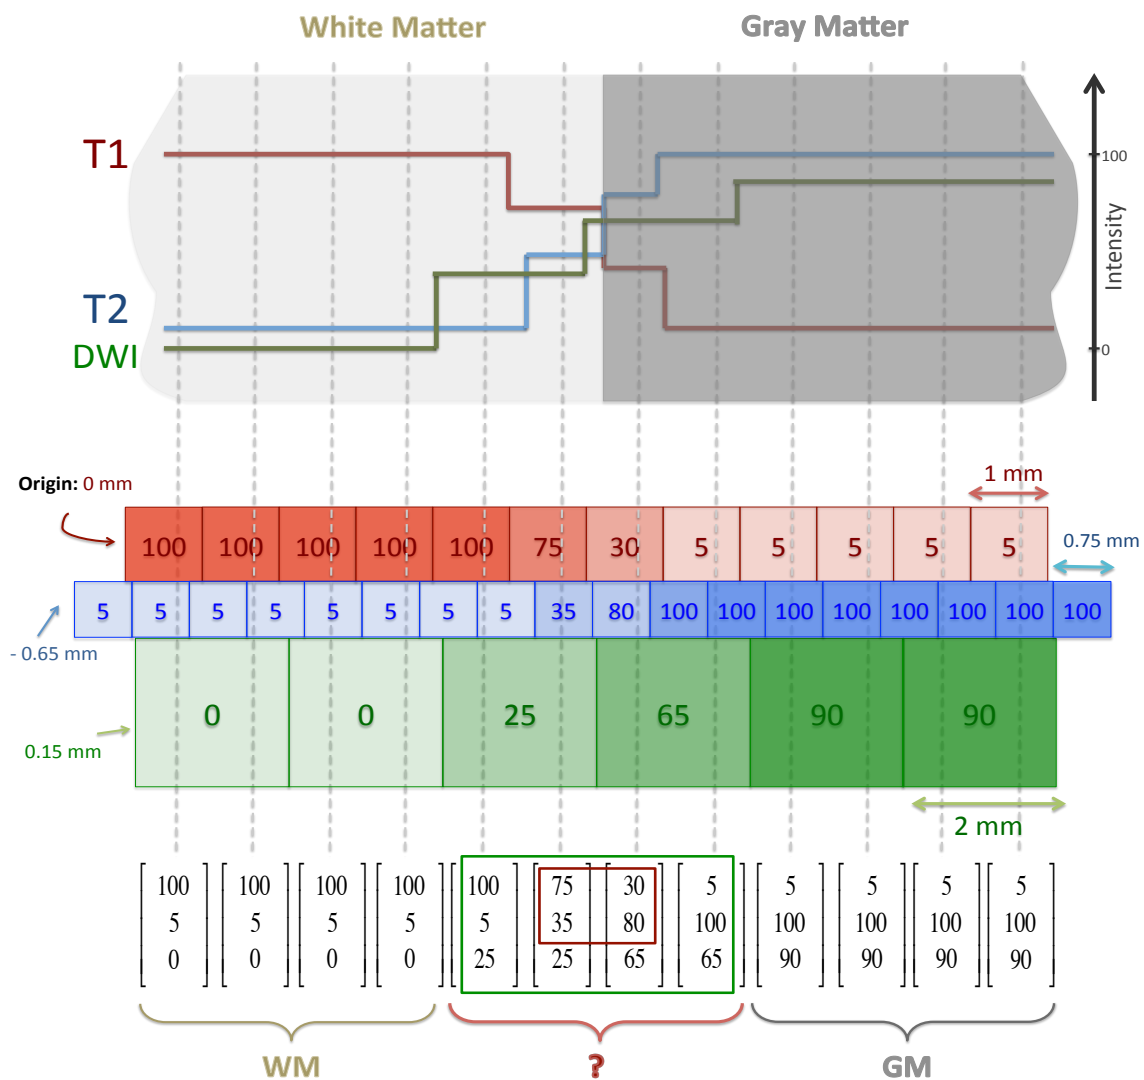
1D demonstration of partial volume effect (PVE) when MRI signals of different modalities are sampled to discretized segments with different spatial resolutions and origins. Question mark represent the sample values that reflect a partial volume composition of more than one tissue type.
